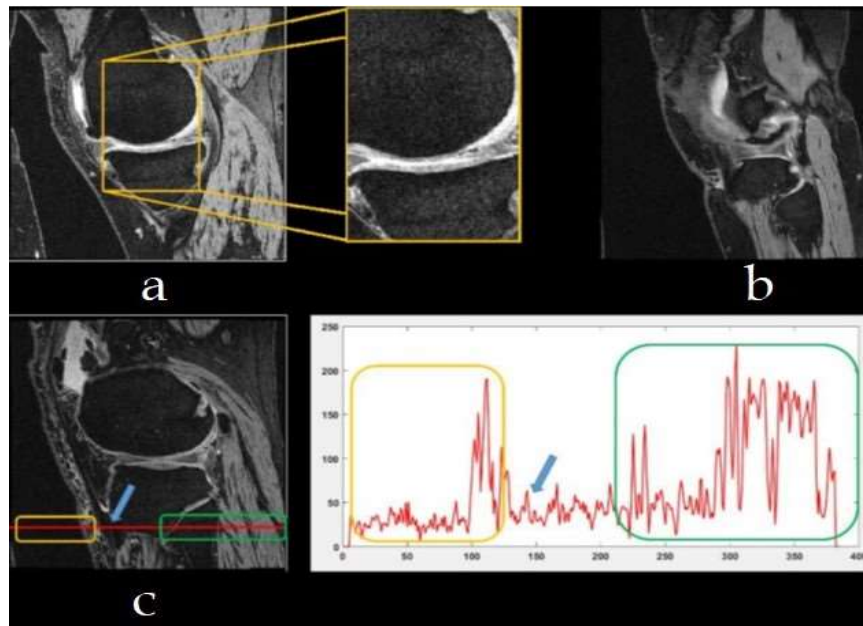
Challenges in MR images (a) Noise present, (b) complex structure of knee, (c) inadequate contrast of knee MR image.
